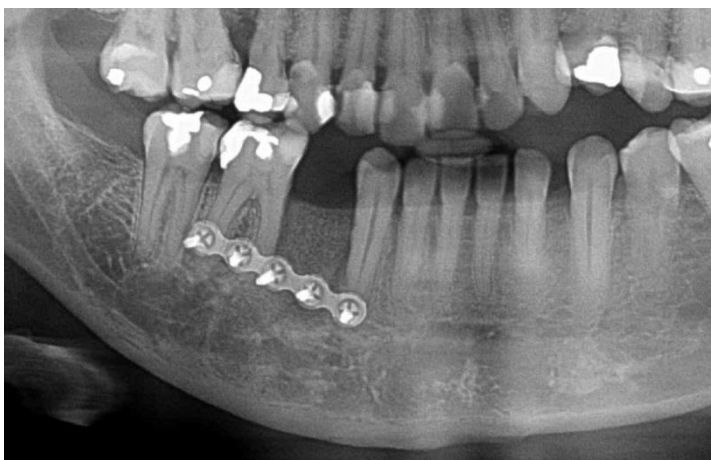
Orthopantomogram at three months follow up.
